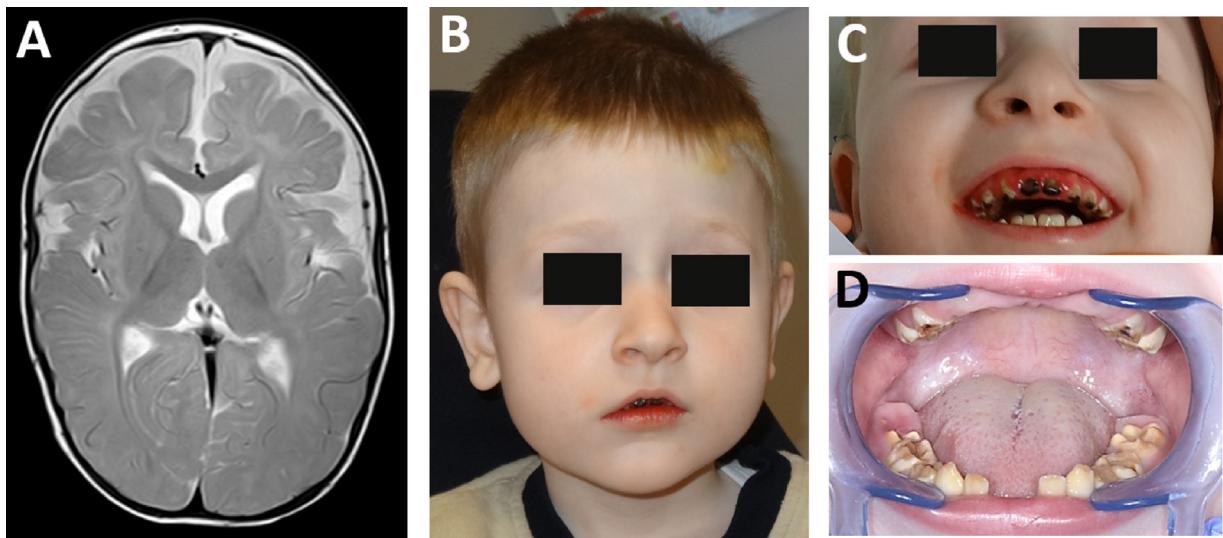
A) T2 wtd MRI at the age of 10 month. Results were widely normal with no structural malformations. Slight widening of external liquor spaces and discrete left frontoparietal parenchymal rarefaction were noted. B) Facial gestalt showed hypotonic impression without overt dysmorphic features. C and D) Enamel defects at 5.5 and 6.8 years respectively.
